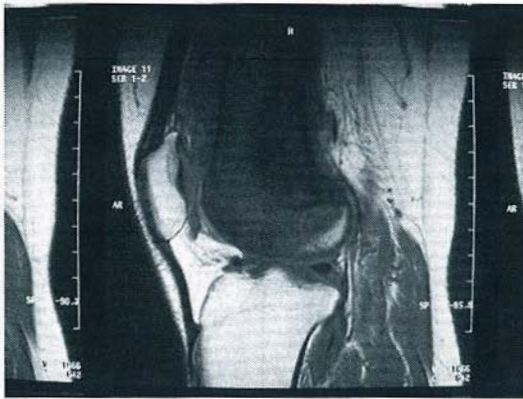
An MR image of the distal femur shows the tumor extension close to the intraarticular joint space.
